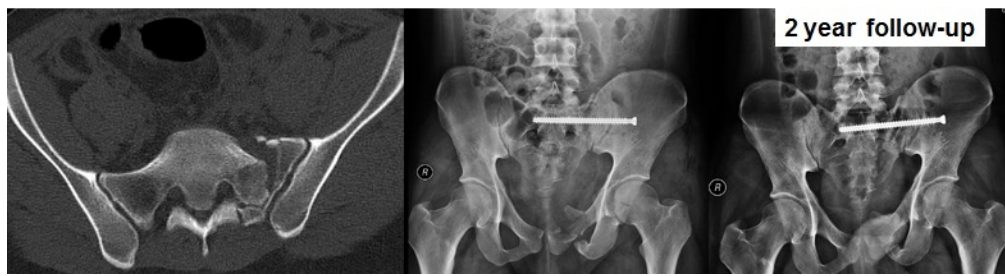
Pre-operative CT-scan and post-operative AP radiographs of a 25-year-old male showing Denis zone-2 injury managed by Sacro-iliac screw
